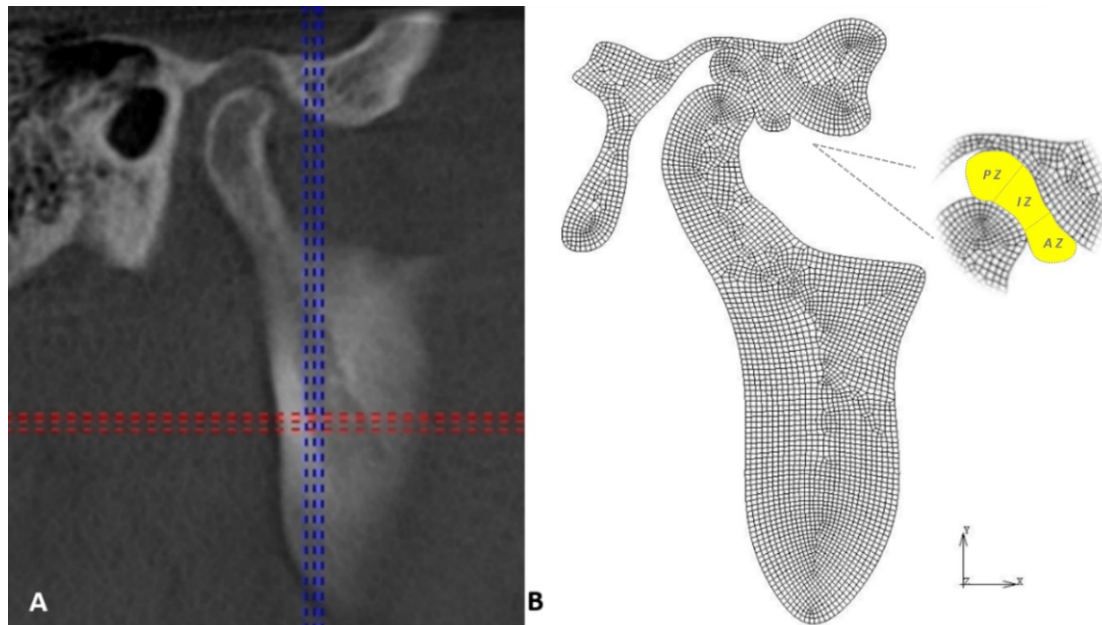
A- CT scan image of section; B- Numerical model and division of the articular disc into three parts: posterior, intermediate and anterior zones.
